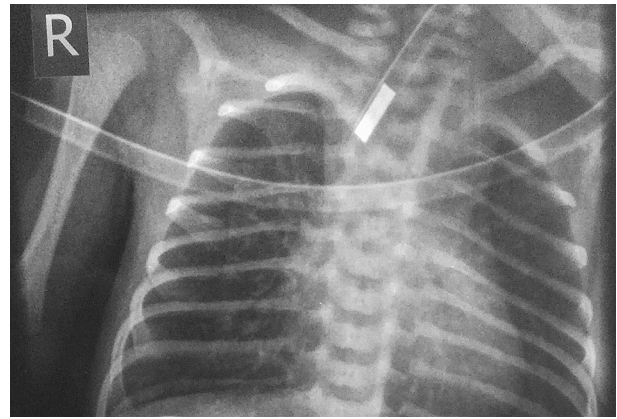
Chest X-ray posteroanterior view of the newborn baby, who was born to a mother with antenatal exposure to olanzapine, suggestive of tracheo-esophageal fistula
